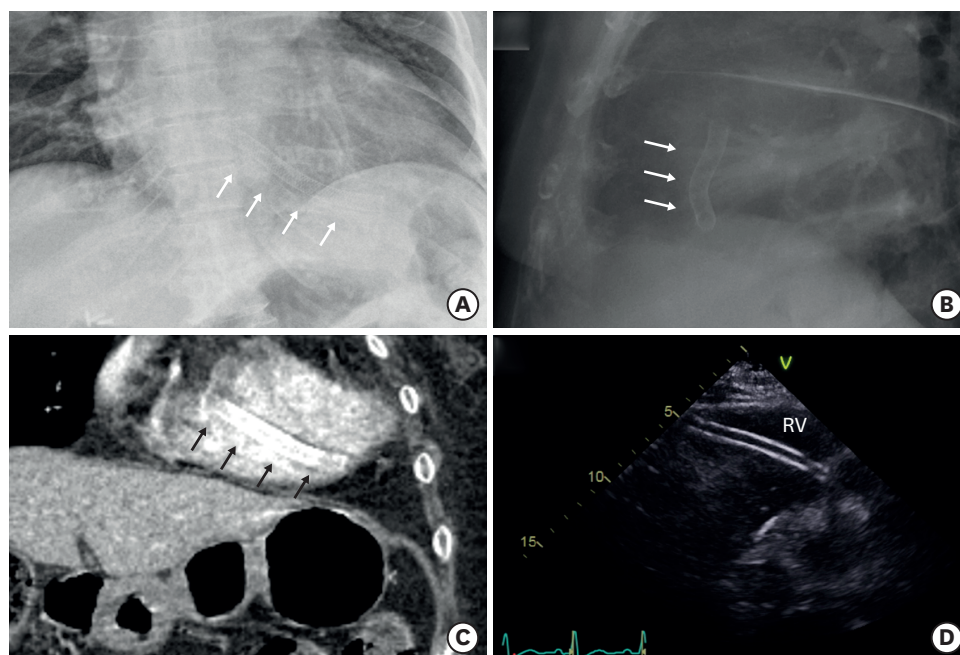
(A, B) Anterior and lateral view of chest X-ray showing the stent presents within the anterior inferior chest (arrows). (C) Coronal view of computed tomography showing the migrated stent in the RV (arrows). (D) Transthoracic echocardiography showed a migrated vascular stent in the RV. RV = right ventricle.
